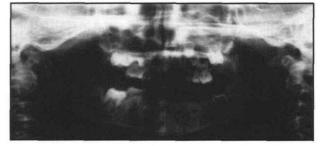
Panoramic radiograph showing normal maxillary dentition and affected mandibular teeth.
